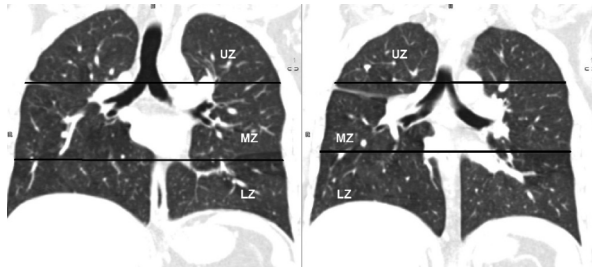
Zonal division of lungs. Computed tomography coronal reformatted images show the division of lungs into upper, middle and lower zones. Upper zone was defined as area above the carina, middle zone as area between carina and junction of inferior pulmonary veins with left atrium and lower zone as the area below the second line.⁽⁹²⁾ UZ: Upper zone, LN: Lower zone, MZ: Middle zone
